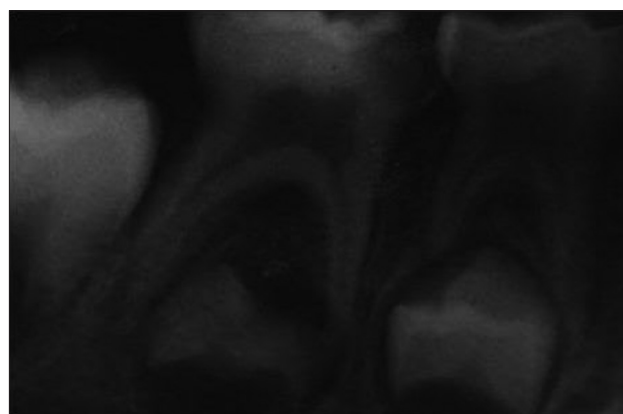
Preoperative radiograph as per the inclusion criteria
